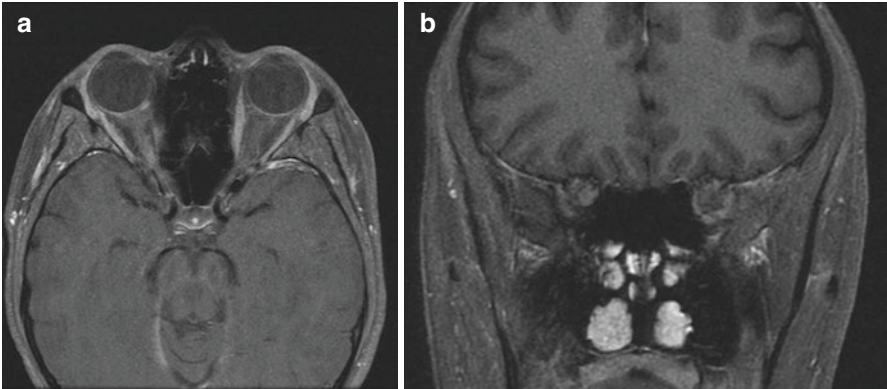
(a) Axial and (b) coronal T1-weighted post-contrast MRI demonstrates enhancement involving the retrobulbar segment of the right optic nerve (© AD Henderson 2021. All Rights Reserved)
